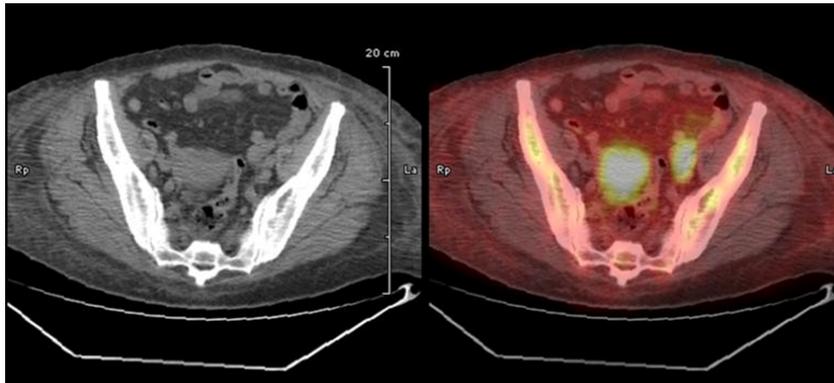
PET CT of the pelvis
